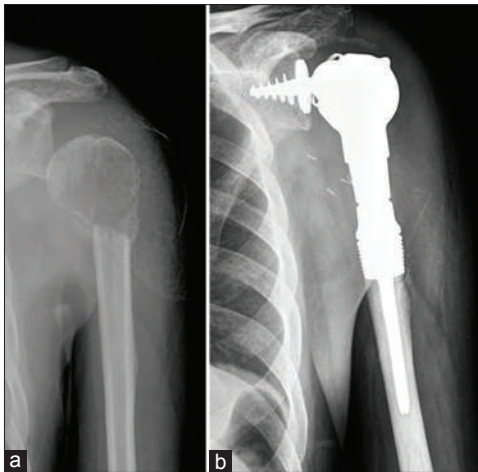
(a) The radiograph depicts a 56-year-old male who presented with a pathological fracture while serving during a game of tennis. Biopsy revealed a metastatic cancer. Positron emission tomography-computerised tomography (PET-CT) showed this to be solitary metastases from renal cell carcinoma (b) Resection and reconstruction with a reverse shoulder type of implant (Stanmore Implants Worldwide, UK) preserving the deltoid muscle and axillary nerve allows better abduction and flexion
